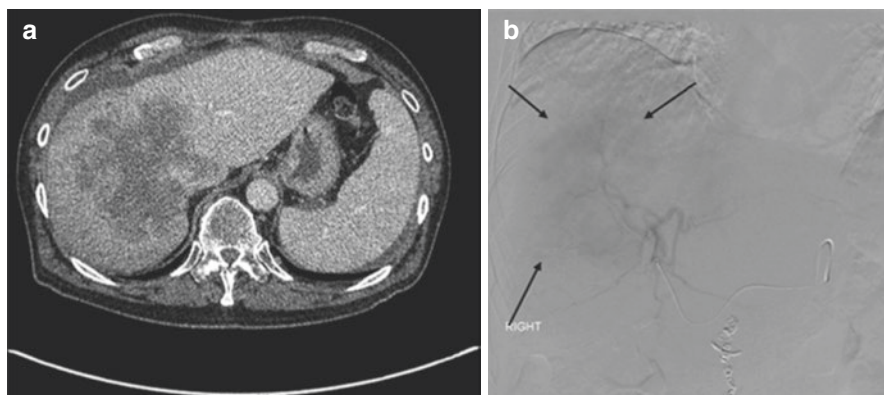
Patient with unresectable liver confined intrahepatic cholangiocarcinoma shown as hypodense mass on axial contrast-enhanced CT (a). Patient underwent Y90 radioembolization (b). Faint tumor blush can be appreciated on this delayed right hepatic artery angiogram
